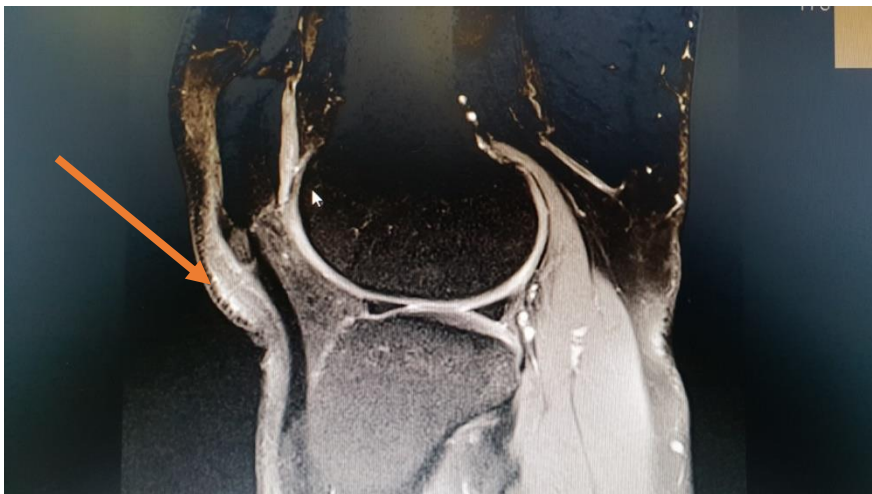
MRI T2 weighted image of right knee.
